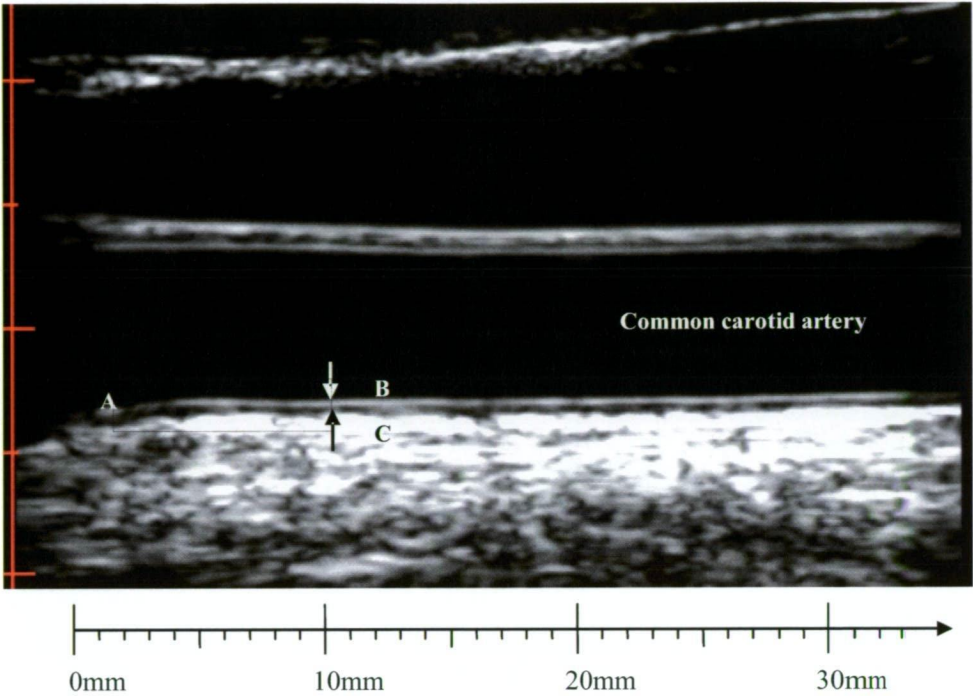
B-mode ultrasound image of the left common carotid artery: A) border of carotid bulb widening (0 mm), B) common carotid artery far wall lumen-intima interface, C) media-adventitia interface. Definitions of the common carotid artery segment in each cohort: Young Finns and CDAH, common carotid artery IMT is taken as the distance between B and C measured in the vicinity 10 mm proximal to the border of the bulb widening (A); Bogalusa, common carotid artery IMT is taken as the distance between B and C measured 0-10 mm proximal to the border of the bulb widening (measurement area highlighted in yellow).
